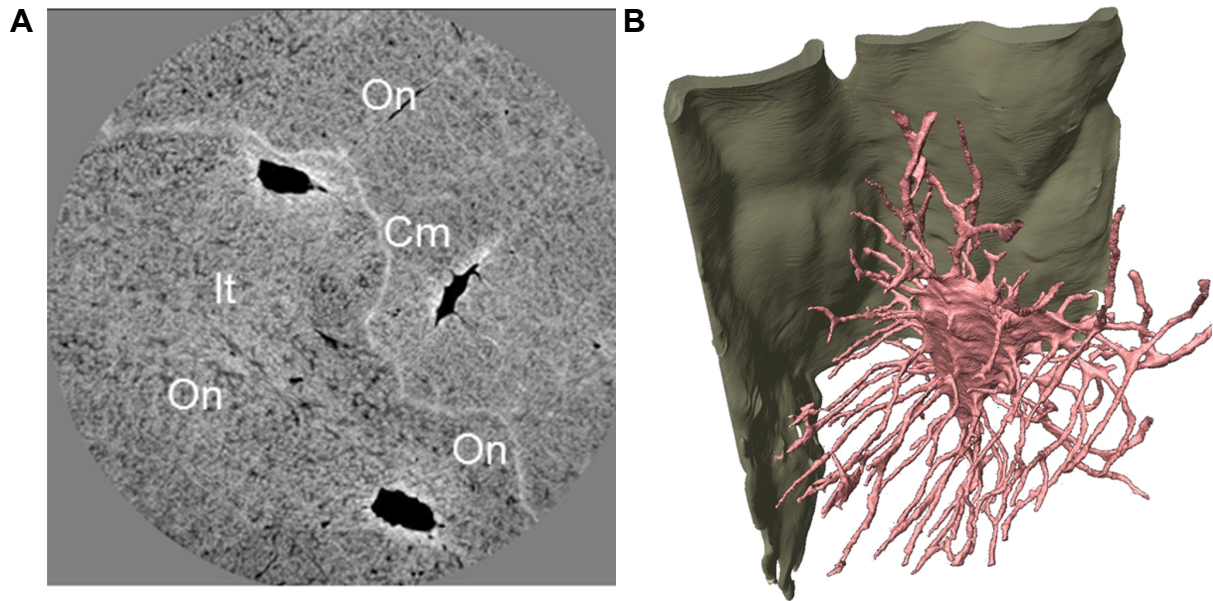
A) Transverse slice through a synchrotron x-ray nanotomography dataset. Empty spaces such as osteocyte lacunae and canaliculi are black. High density mineral is white. On = osteonal bone. It = interstitial bone. Cm = cement line. Field of view is approximately 100 μm . B) Computer generated 3-D rendering of a single osteocyte lacuna with associated canaliculi (pink) adjacent to a cement line (green) taken from the dataset in A). Images reproduced under Creative Commons Attribution Licence from Langer *et al.*¹⁵⁰
